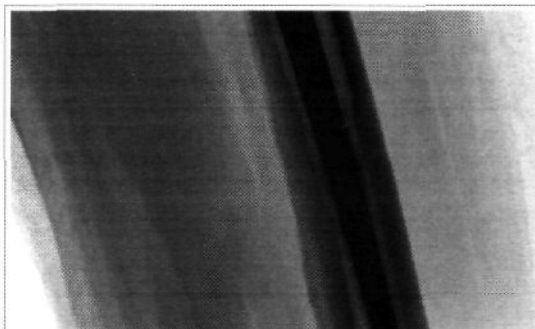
Case 3: Magnified view of the same radiograph showing the fractured stem
